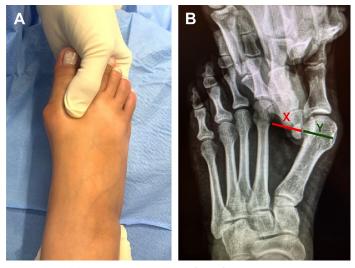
(A) Clinical and (B) radiographic image of the first ray squeeze test. Observe that a 100% lateral displacement of the metatarsal head covers the first intermetatarsal space. The first metatarsal head size (*green line*; Y) is equal to the intermetatarsal space (*red line*; X).
